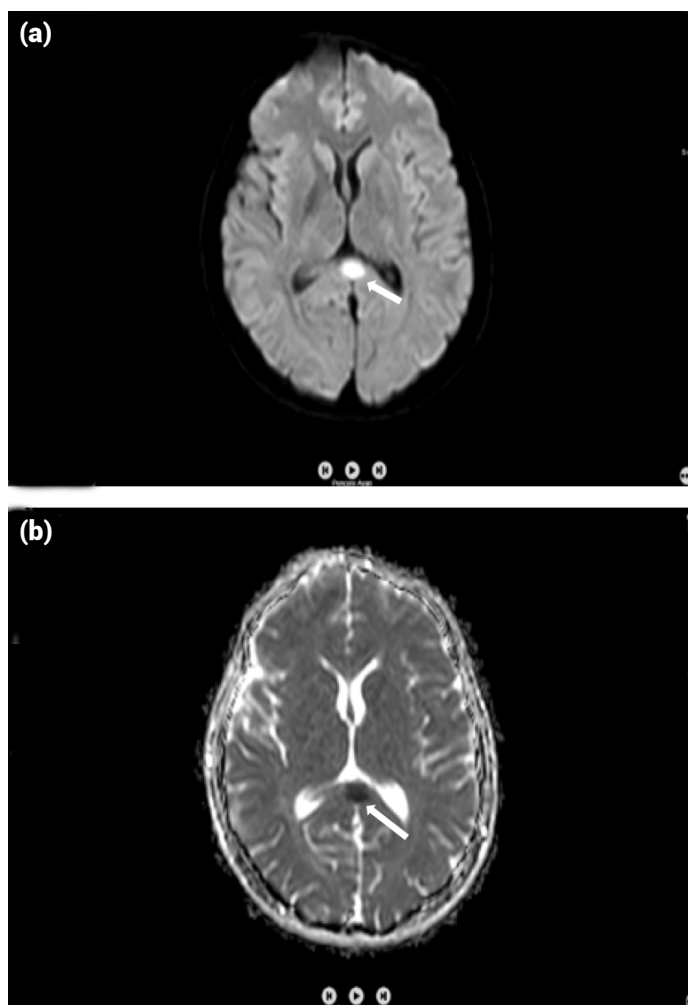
Case 1; (a) Arrow showing nodular acute diffusion restriction in the splenium of the corpus callosum on diffusion MRI; (b) The corresponding anatomical parts exhibited drop-out hypointense character on the apparent diffusion coefficient (ADC) mapping.
